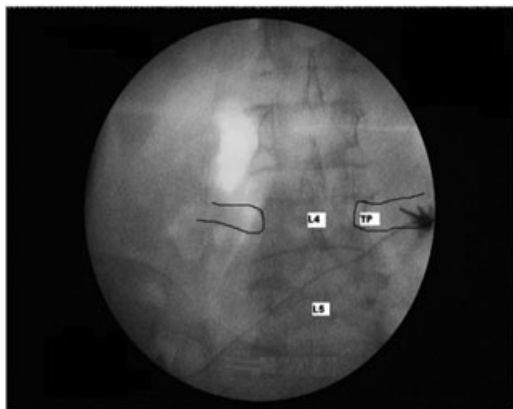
Radiograph showing block needle close to L4 transverse process.
